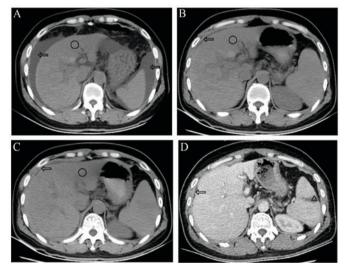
Abdominal CT scans of the patient. (A) Abdominal CT scan on day 5 after admission indicated liver deformation, shrinkage of the liver, border irregularity, a low-density shadow with border blurring (circle), ascites (arrows) and splenomegaly. (B) Abdominal CT scan on day 21 indicated that the size of the liver had recovered, ascites (arrows) were decreased and the low-density shadow (circle) was similar to the previous CT. (C) Abdominal CT on day 52, indicated that the low-density shadow (circle) had decreased and its border was clear, and ascites (arrows) were not present. (D) Contrast-enhanced CT scan on day 54 indicated hepatic cirrhosis, liver deformation, an infarction of the spleen (triangle) and an absence of ascites (arrows). Compared with previous CT scans, the low-density shadow was not evident. CT, computed tomography.
